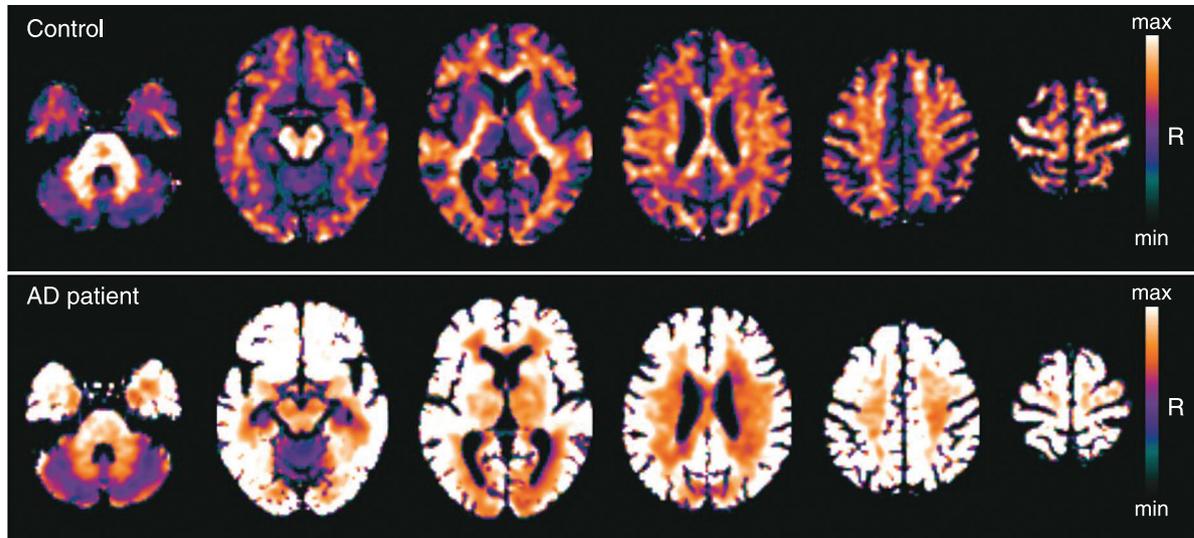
Positron emission tomography (PET) images acquired after intravenous injection of Pittsburgh compound B labeled with carbon-11 (^{11}C -PiB) to map the anomalous deposition of extracellular amyloid plaques formed by amyloid β -peptide ($\text{A}\beta$) in the cerebral cortex. Top panel: transaxial slices from a usual ^{11}C -PiB PET dataset obtained from a healthy elderly volunteer, with very low tracer uptake in the cortex relative to white matter uptake. Bottom panel: ^{11}C -PiB PET data from a patient suffering from dementia compatible with Alzheimer's disease (AD), with increased tracer uptake in the frontal, temporal, parietal, and cingulate cortices. Both datasets underwent automated processing typically employed in quantitative neuroimaging research studies, including spatial normalization to a standardized anatomical template (using the Statistical Parametric Mapping program) and correction for partial volume effects based on information from volumetric magnetic resonance imaging (MRI) datasets obtained from the same individuals. The original, preprocessed PET images were obtained in collaboration with scientists from the Centro de Medicina Nuclear, Instituto de Radiologia, Hospital de Clínicas, Faculdade de Medicina, Universidade de São Paulo, under the leadership of Dr. Daniele de Paula Faria and Prof. Carlos A. Buchpiguel.
